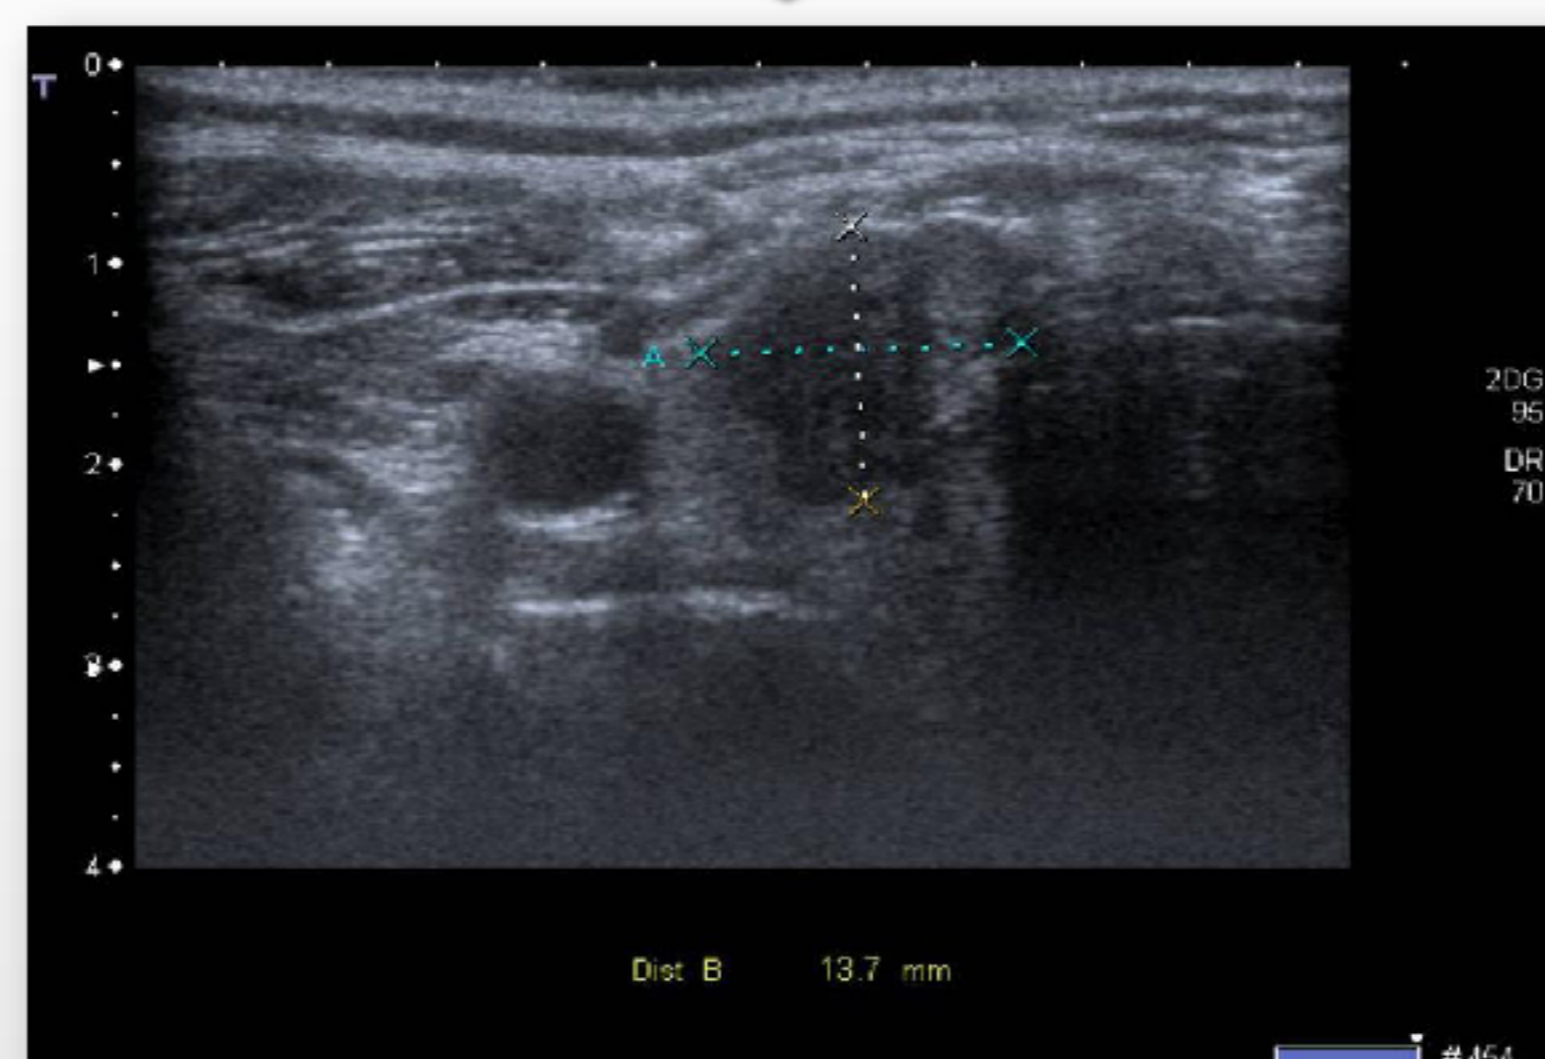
Thyroid ultrasound: 2cm hypoechoic solid nodule with irregular margins and 12mm partial cystic nodule on the right lobe (TIRADS 4c)
